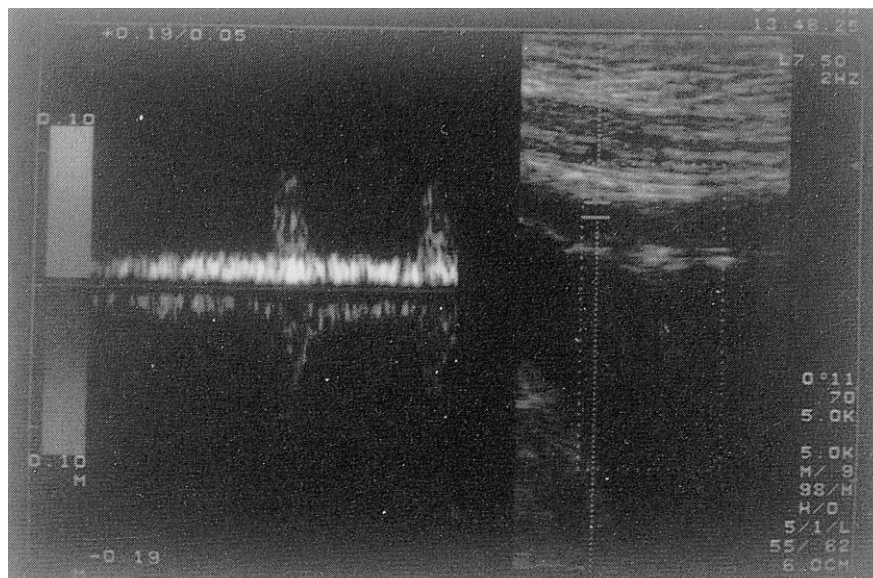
Color Doppler flow image of the anterior bladder wall in a 64 year-old male patient with infravesical obstruction due to benign prostatic hyperplasia. The ultrasound estimated bladder weight was 47.4 g. The sound spectrogram showed a pulsatile blood flow.
